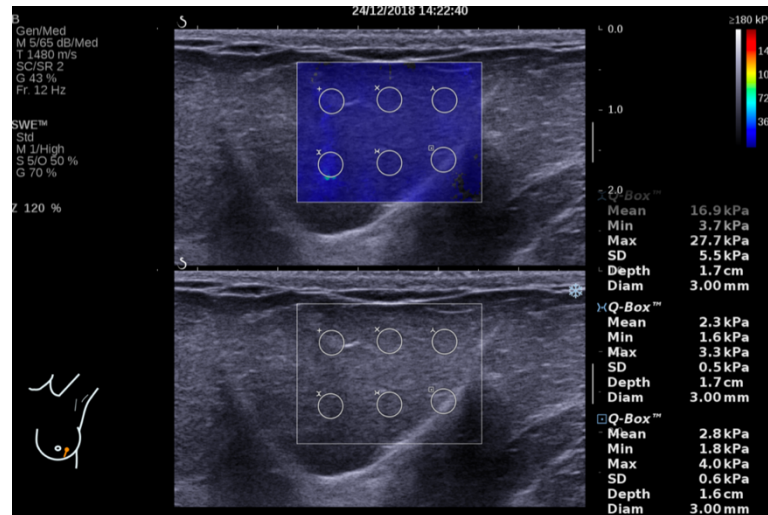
Shear wave ultrasound output with six 3mm Q-Box™ and the elasticity measurements
